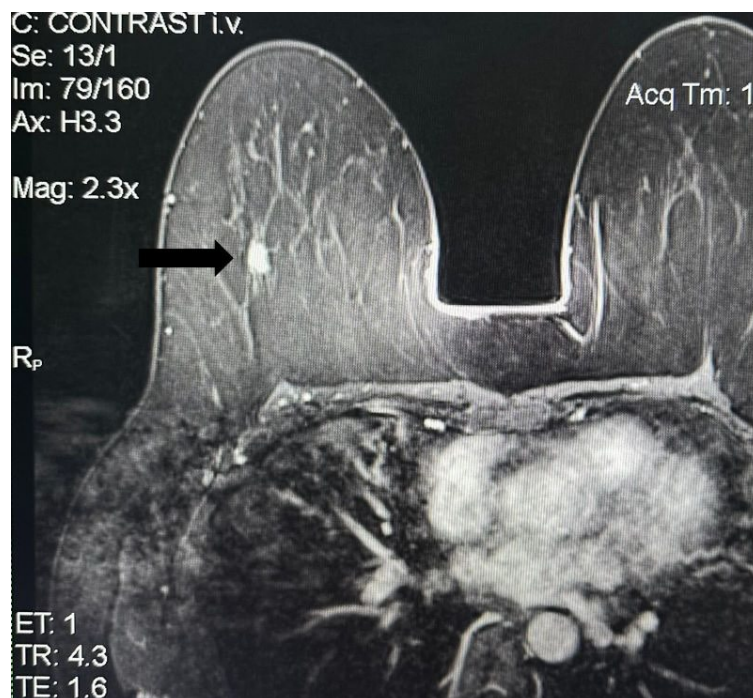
MRI image showing right breast nodule (arrow).
